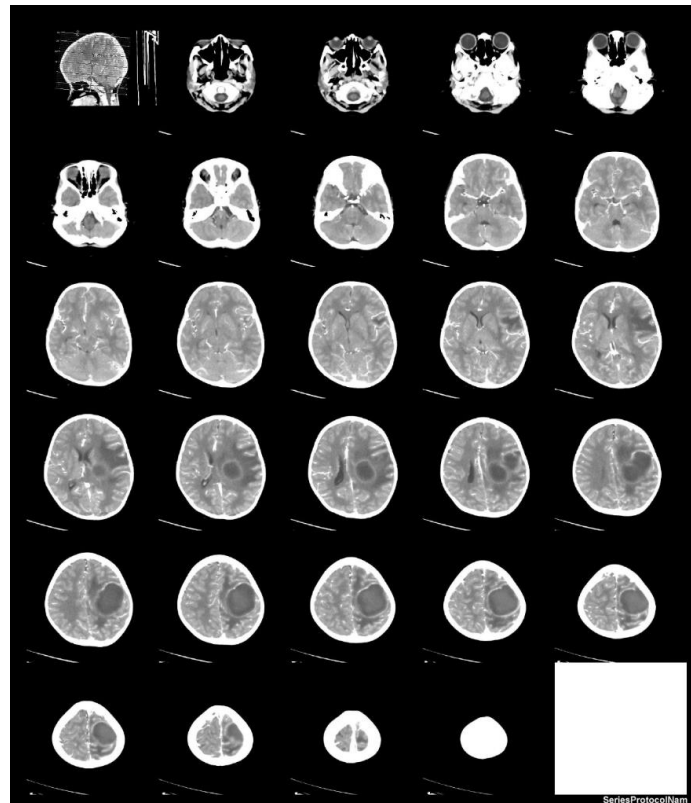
Contrast-enhanced cranial CT scan showing a hypodense lesion in the left parietal lobe with ring enhancement, consistent with a cerebral abscess.
